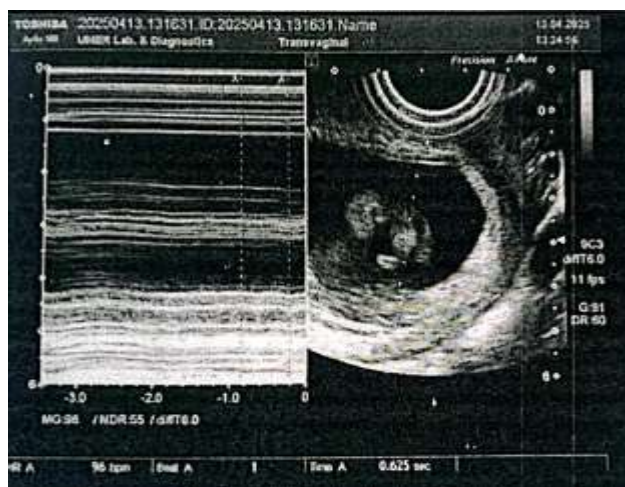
Transvaginal ultrasound scan showing increase heartrate (Tachycardia). The B-mode image (right) displays a gestational sac with a fetal pole, while the M-mode trace (left) displays a gestational sac with a fetal pole.
